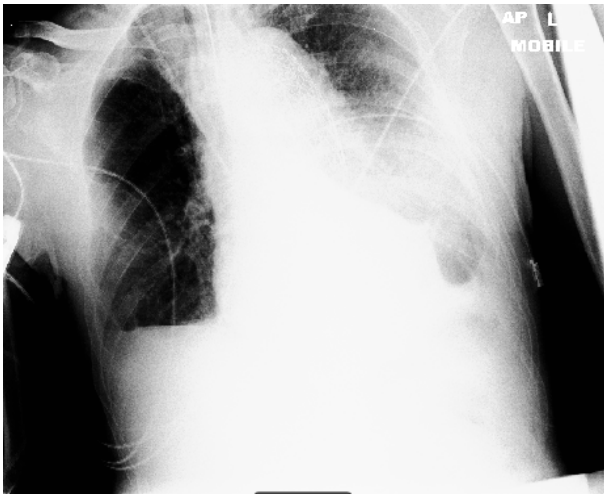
Chest radiograph of Mr X taken post-operatively showing pleural haematomas and a misplaced NG tube.
